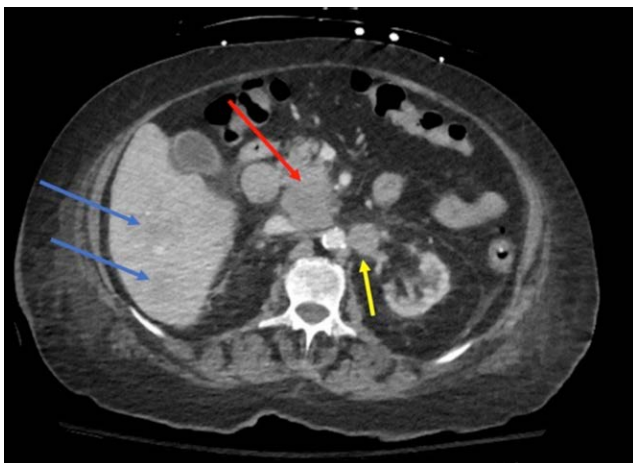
Axial view of CT Abdomen showing multiple intra-abdominal masses and extensive adenopathy consistent with PTLD. Blue arrows: liver metastasis; red arrow: large intra-abdominal mass; yellow arrow: para-aortic adenopathy. PTLD, posttransplant lymphoproliferative disorder.
